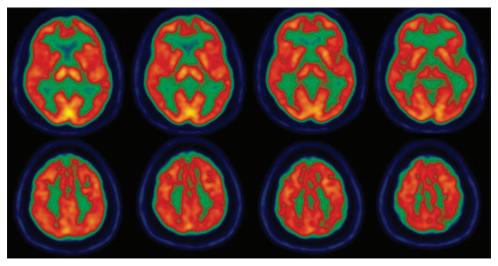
Brain F-18 FDG PET of our patient. The right electrode was ON and the left electrode was OFF during the study. The study shows no difference in metabolic activity between the two hemispheres despite the difference in electrical stimulation
